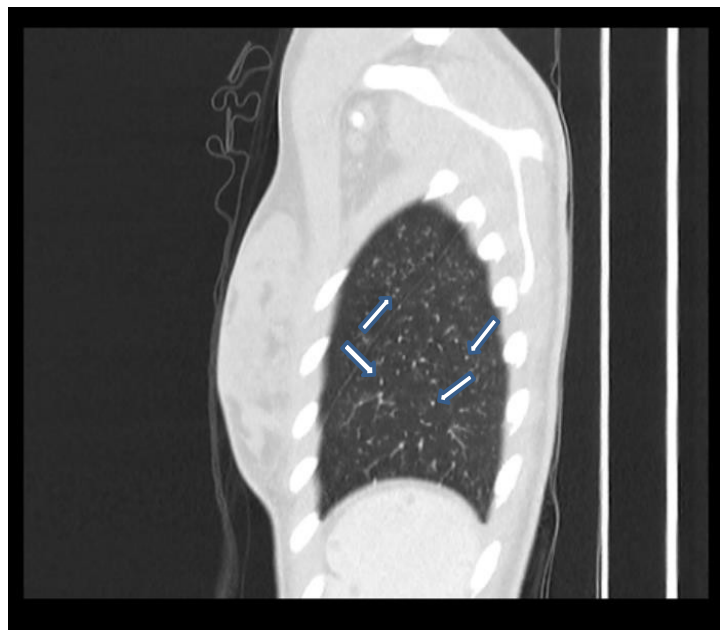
CT thorax (lateral view) showing multiple miliary nodules (tubercules) indicated by the white arrows.
